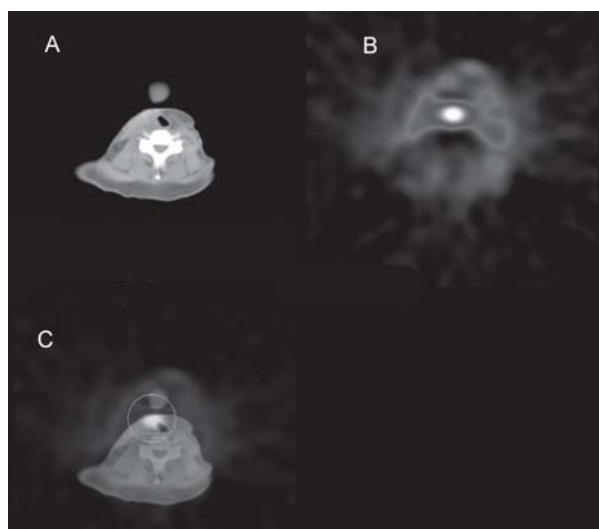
PET/CT image in a recurrent larynx cancer. 1A – CT image; 1B – PET image; 1C – PET/CT fused image
